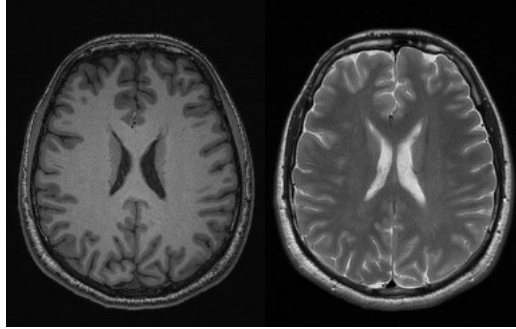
T1-weighted (left) and T2-weighted (right) magnetic resonance images in a healthy person.
